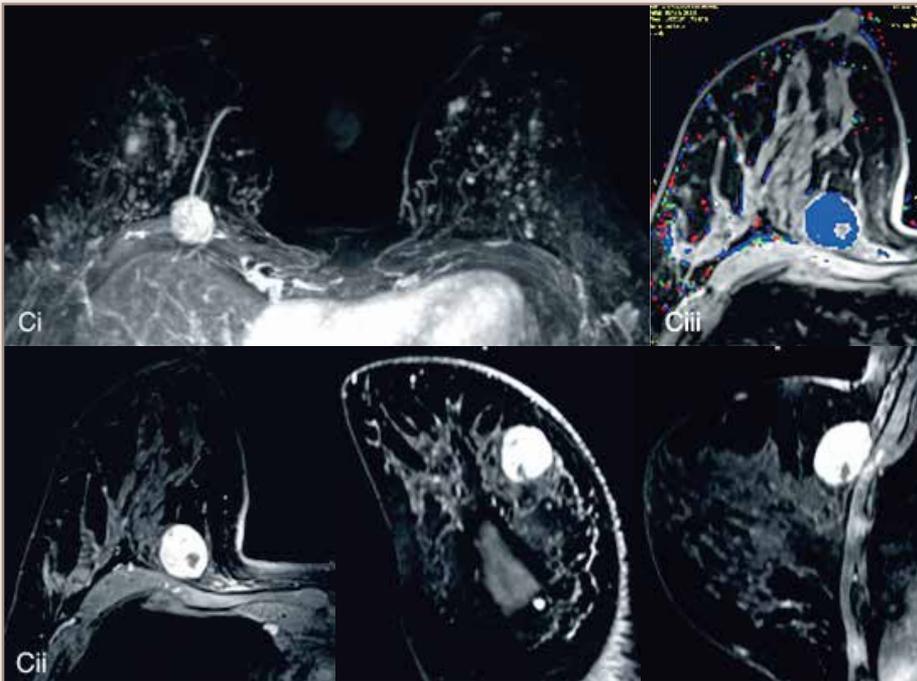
Pathology was inconclusive. MR enclinch the diagnosis. MRI mimic subtraction MIP (minimum intensity projection) image shows an enhancing mass in the right breast along with multiple enhancing foci in both breasts. MRI, axial, coronal and sagittal reformatted dynamic postcontrast fat suppressed GR image of the right breast shows a circumscribed fairly homogeneously enhancing mass at the 2:30' clock axis in the posterior depth close in the chest wall. Corresponding computer aided design (CAD) image: shines persistent kinetics depicted as blue color on the color code CAD map. Source: Image Courtesy: De Sangeeta Taneja, Indraprastha Apollo Hospital, Delhi).
